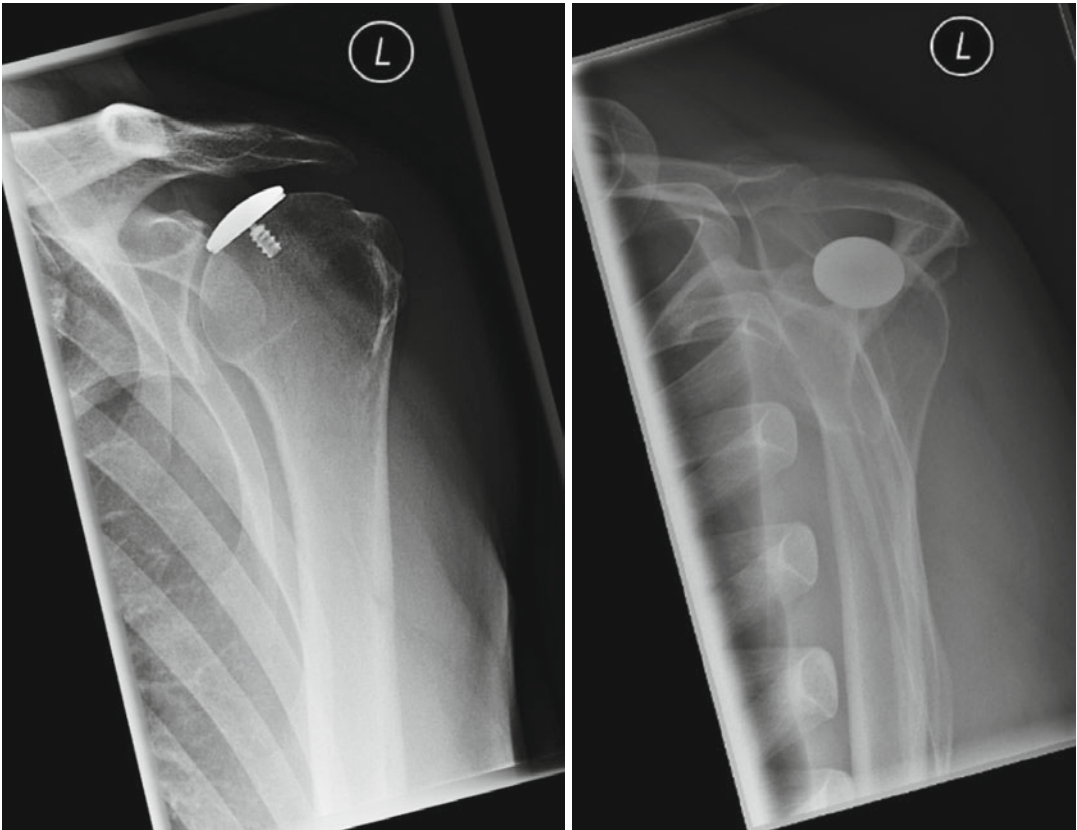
Postoperative radiography after Partial Eclipse implantation with a posterosuperior cartilage lesion
